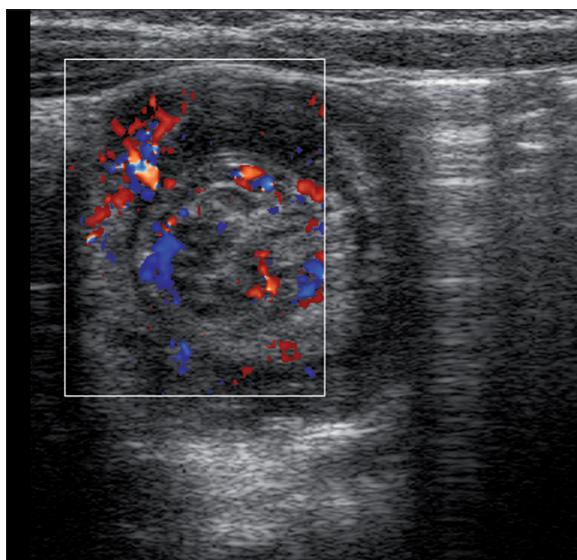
Color Doppler examination showing the blood flow in the wall of the intussusception.
